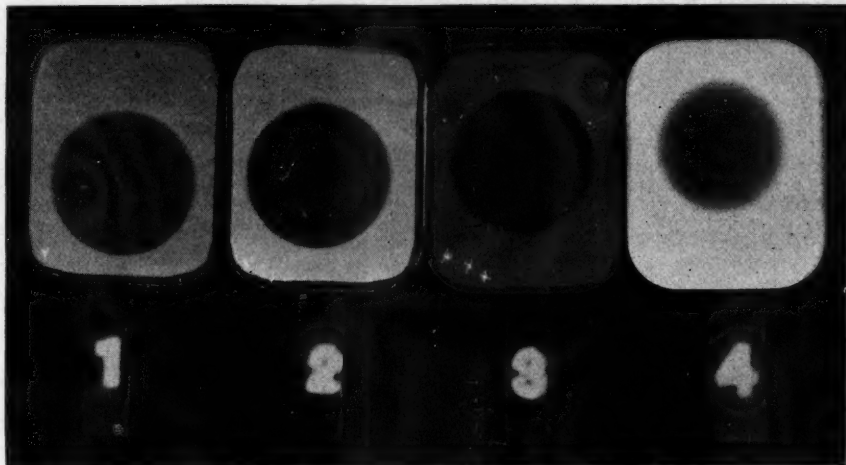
Tests of secondary and stray radiation. 1, Film with coin attached protected from the primary rays but exposed to secondary radiation from wood 6 inches from the film. 2, Radiographic image of coin produced by secondary rays from sheet steel 6 inches distant. 3, The result of secondary radiation from sheet lead 6 inches distant. 4, Radiogram of a coin by primary rays through an oak door 1 inch thick, two feet from the tube. A 30-second exposure was given in each test.
